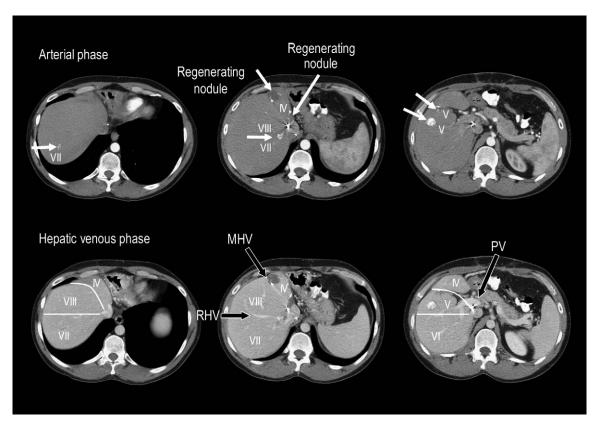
A triphasic CT scan of the first patient taken 5 months after resection of the metastases in the left hemi-liver. Segments II and III have been resected along with the metastasis situated between the MHV and IVC. Metastases in the right hemi-liver are indicated by *white arrows*, and the number indicates the hepatic segment that is involved. Each metastasis is only numbered once. The RHV, MHV, and portal vein (PV) are indicated by *black arrows*. The segment IV remnant is undergoing regeneration.
